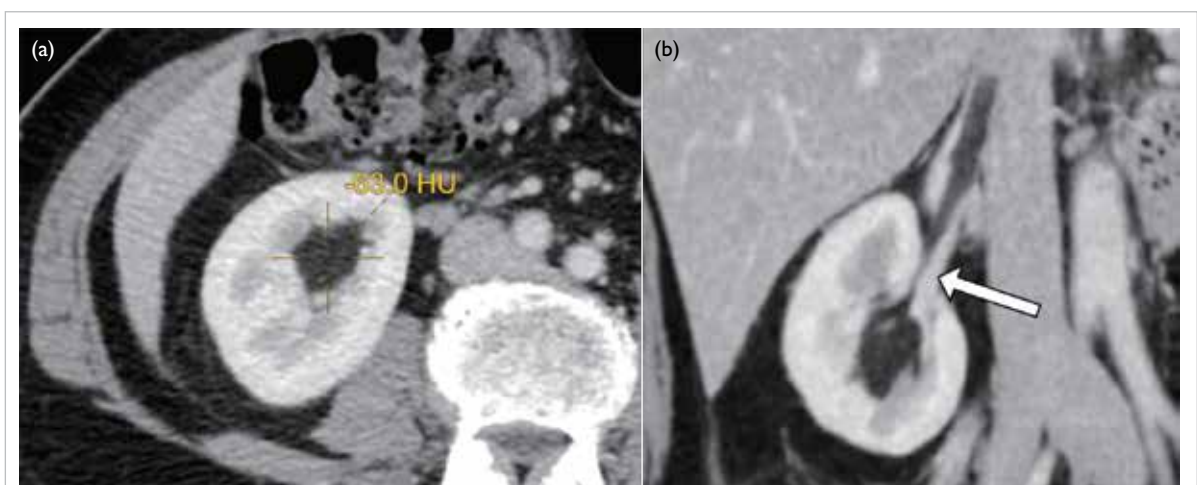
(a) Axial and (b) sagittal contrast-enhanced computed tomography images of the patient show a homogeneous fat-density mass of -63 Hounsfield units at the right renal sinus with extension into the right renal vein and inferior vena cava (arrow in [b])
